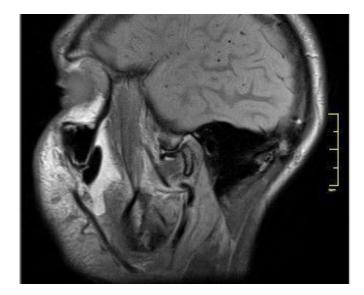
MRI image of disc protrusion
